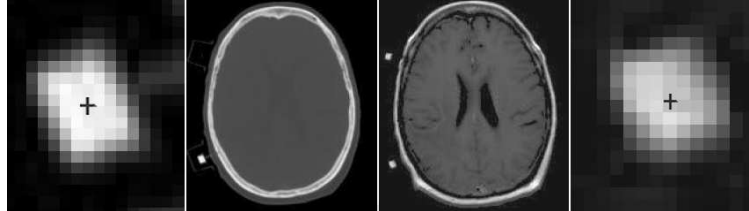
extrinsic landmark-based CT-MR registration, and extracted points from marker regions, adapted from [FHM00]
